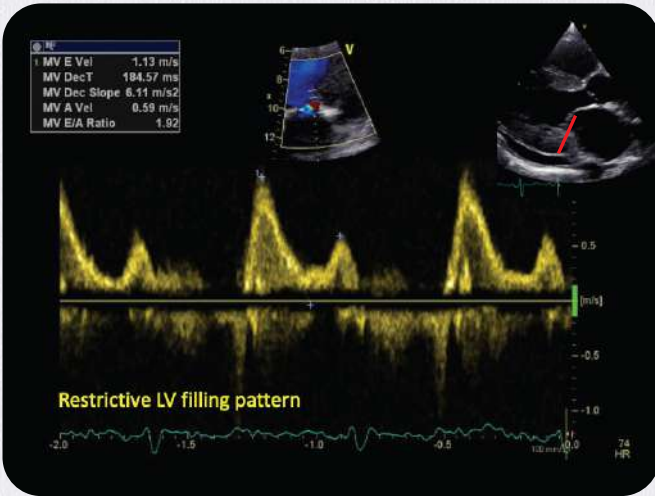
Doppler echocardiography shows a restrictive filling pattern on spectral Doppler across the mitral valve (E/A=1.92)
